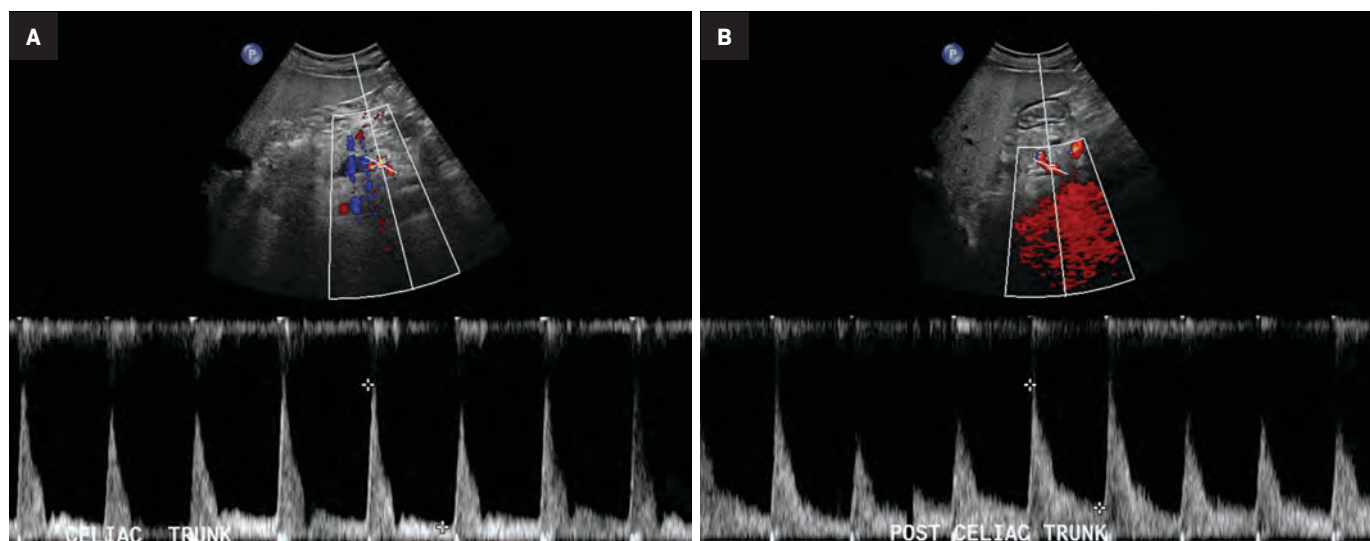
Fasting (A) and postprandial (B) duplex sonography of the CA showing normal waveforms with continuous forward flow and a PSV of 225 cm/s in the fasting state and 298 cm/s in the postprandial state. This constitutes a normal postprandial rise in PSV (32%).
